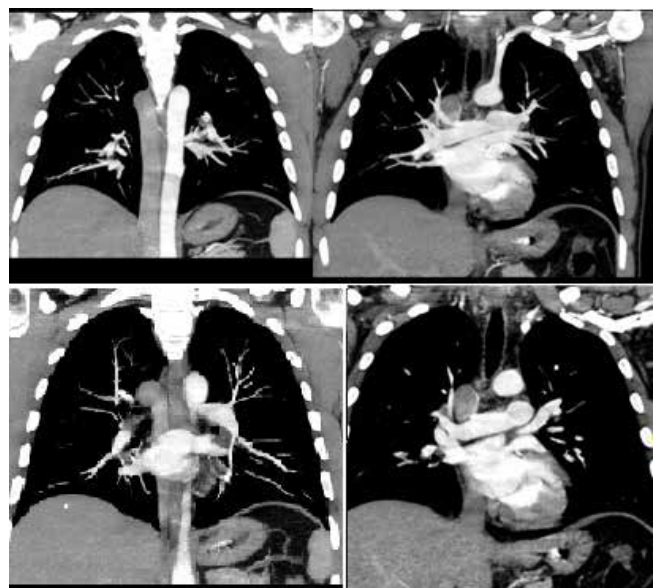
The coronal enhanced CT view shows, enlarged azygos vein descending aorta on the right side and drain into the vena cava superior. Vena cava inferior hepatic segment is not detected and hepatic veins directly drain into the right atrium.
